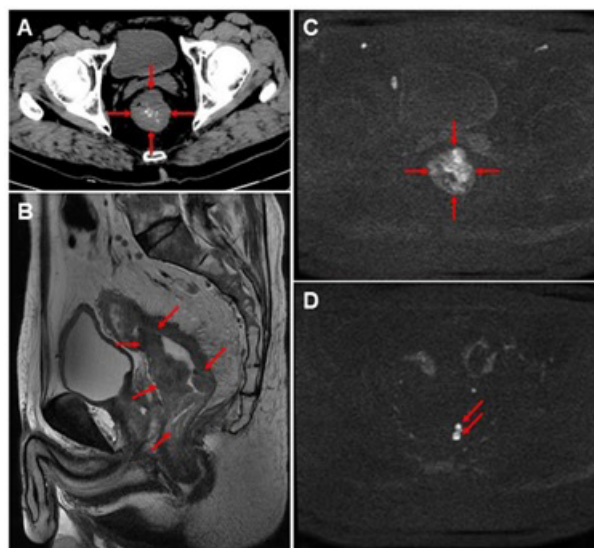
Imageological examination. (A) CT showed the thickening of the rectal wall (red arrows). (B) MRI showed the tumor involved 60 mm rectal wall and located 30 mm from anal margin. Red arrows indicated the tumor. (C) The high signal mass (red arrows) under MRI examination showed the tumor. (D) The red arrows indicate the suspected lymph nodes.
